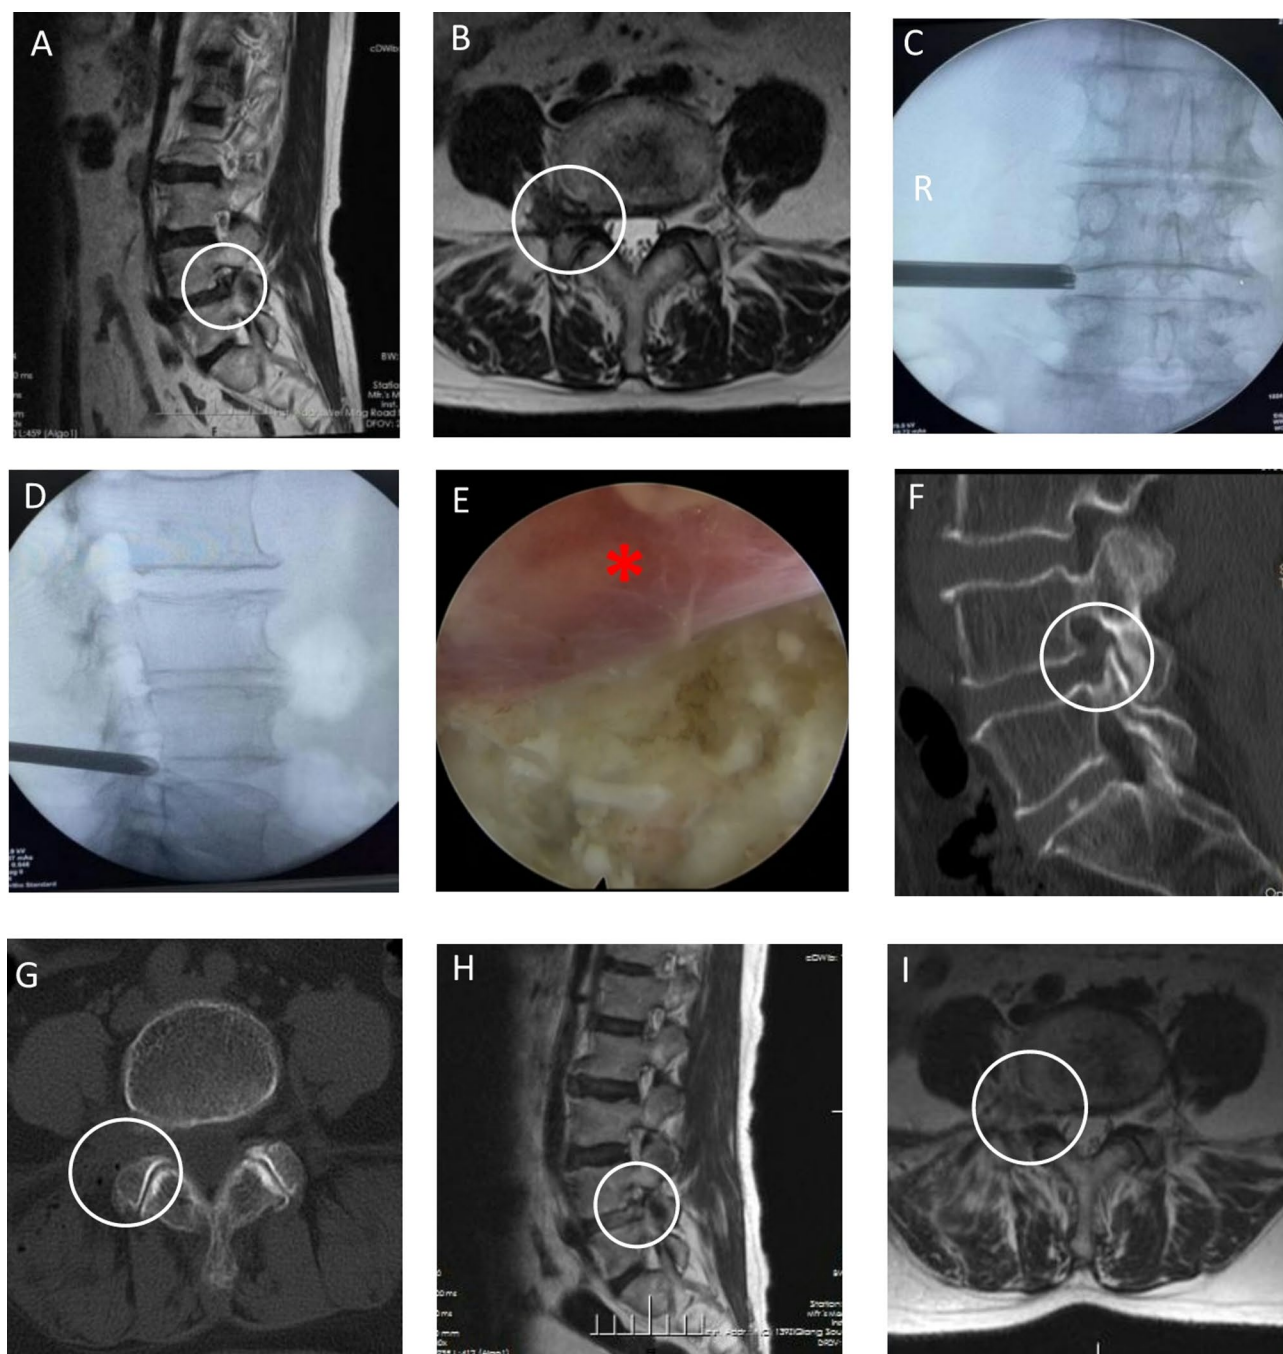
A 33-year-old female patient diagnosed with L4-5 far lateral lumbar disc herniation underwent the PELD surgery. a and b, Preoperative magnetic resonance images (MRI) showing disc herniation (within the circle). c and d, In the anteroposterior view, the working channel was located in the extraforaminal region, while in the lateral view, the anterior edge of the working channel was aligned with the posterior edge of the disc. e, Sufficient decompression of the exiting nerve root (asterisk) was ensured. f and g, One-day postoperative vertebrae computed tomography (CT) scans showed better preservation of the superior articular process (within the circle). h and i, MRI scans 12 months after the surgery showed the herniated nucleus pulposus was thoroughly excised (within the circle)
